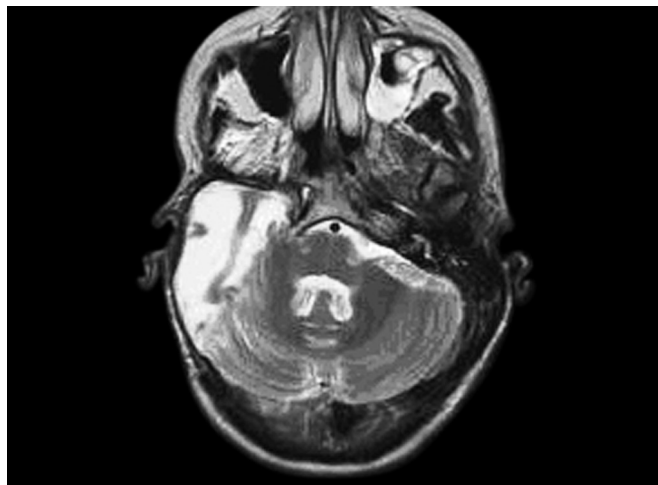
Computed tomography (CT) of the brain and internal auditory canals revealing a right skull base chondrosarcoma measuring at least 5 cm with a small area of extra-axial extension into the right posterior fossa over the cerebellar hemisphere.
